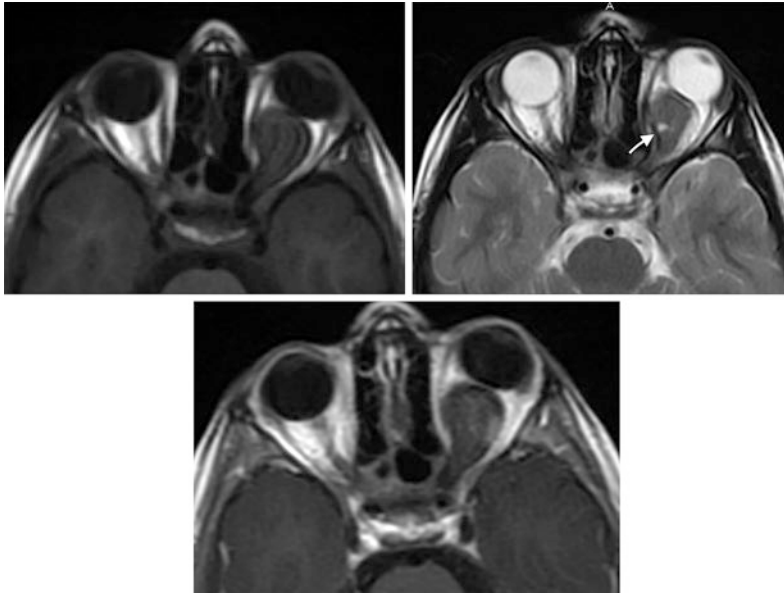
Isolated optic nerve glioma in a 6-years old boy. a–c Axial T1, axial T2WI and post contrast T1WI MR images demonstrate left optic nerve globular shaped mass of hypointense T1 and hyperintense T2 signal with mild post contrast enhancement. Note the presence of small area of cystic degeneration inside the lesion (arrow)
